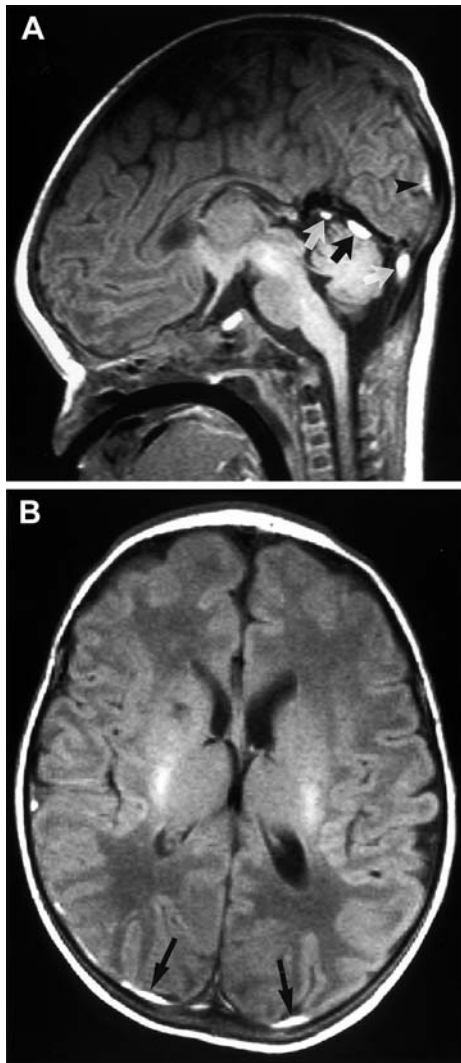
Patient 5: subdural hemorrhage. A Sagittal T1-weighted image shows infratentorial high-signal subdural blood (*arrows*) and a small supratentorial hemorrhage (*arrowhead*). B Axial T1-weighted image shows bilateral small supratentorial subdural hematomas (*arrows*), larger on the right
